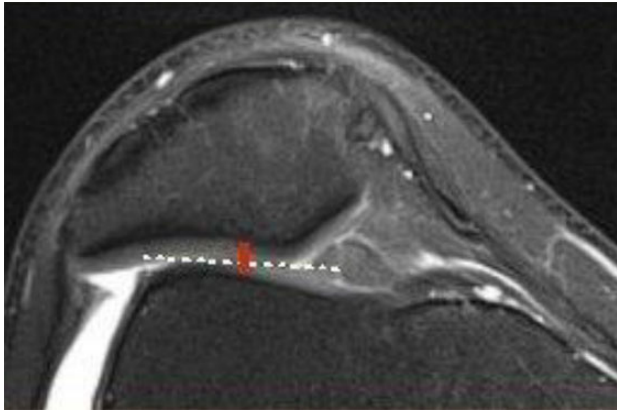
Magnetic resonance imaging scan demonstrating how the cartilage height on the patella (red line) and the lateral facet of the trochlea (dashed white line) was measured.
